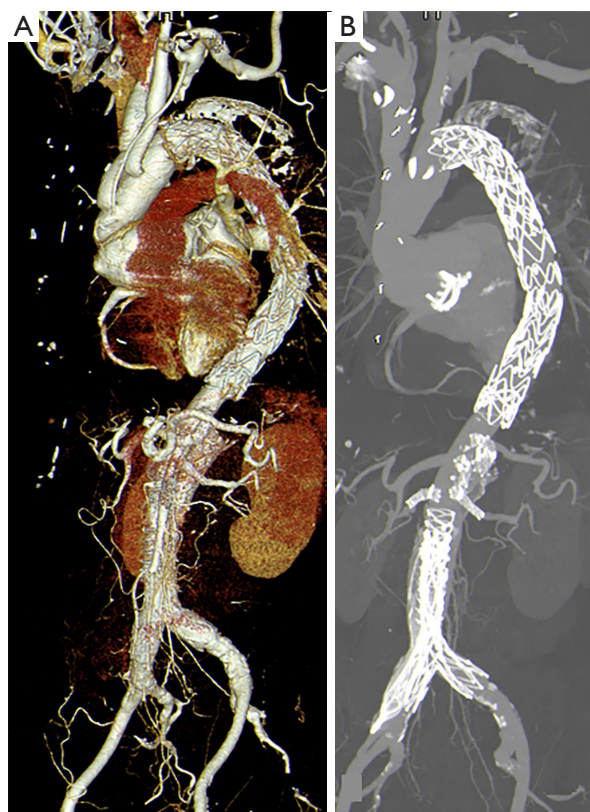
Postoperative computed tomography angiography following total aortic repair and replacement. (A) Three-dimensional volume rendering demonstrating the FET graft with incorporation of the supra-aortic branches and the distal extension into the descending thoracic as well as abdominal aorta. (B) Maximum intensity projection confirming patency of the supra-aortic and thoracoabdominal branches with preserved distal aortic perfusion. FET, frozen elephant trunk.
